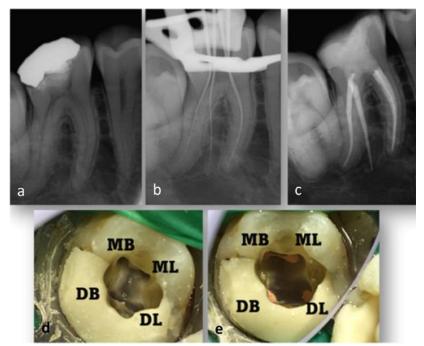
RCT of a mandibular molar with a radix entomolaris. (a) initial radiograph, (b) working length determination, (c) after filling, (d) canal orifices before filling, (e) canal orifices after filling.
